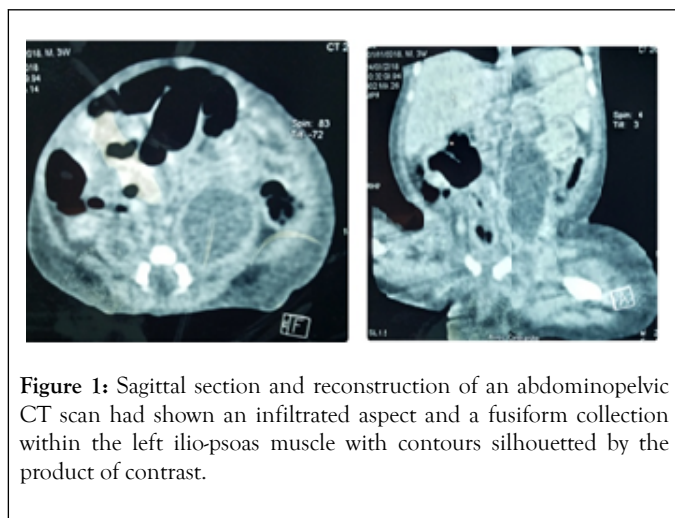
Sagittal section and reconstruction of an abdominopelvic CT scan had shown an infiltrated aspect and a fusiform collection within the left ilio-psoas muscle with contours silhouetted by the product of contrast.
